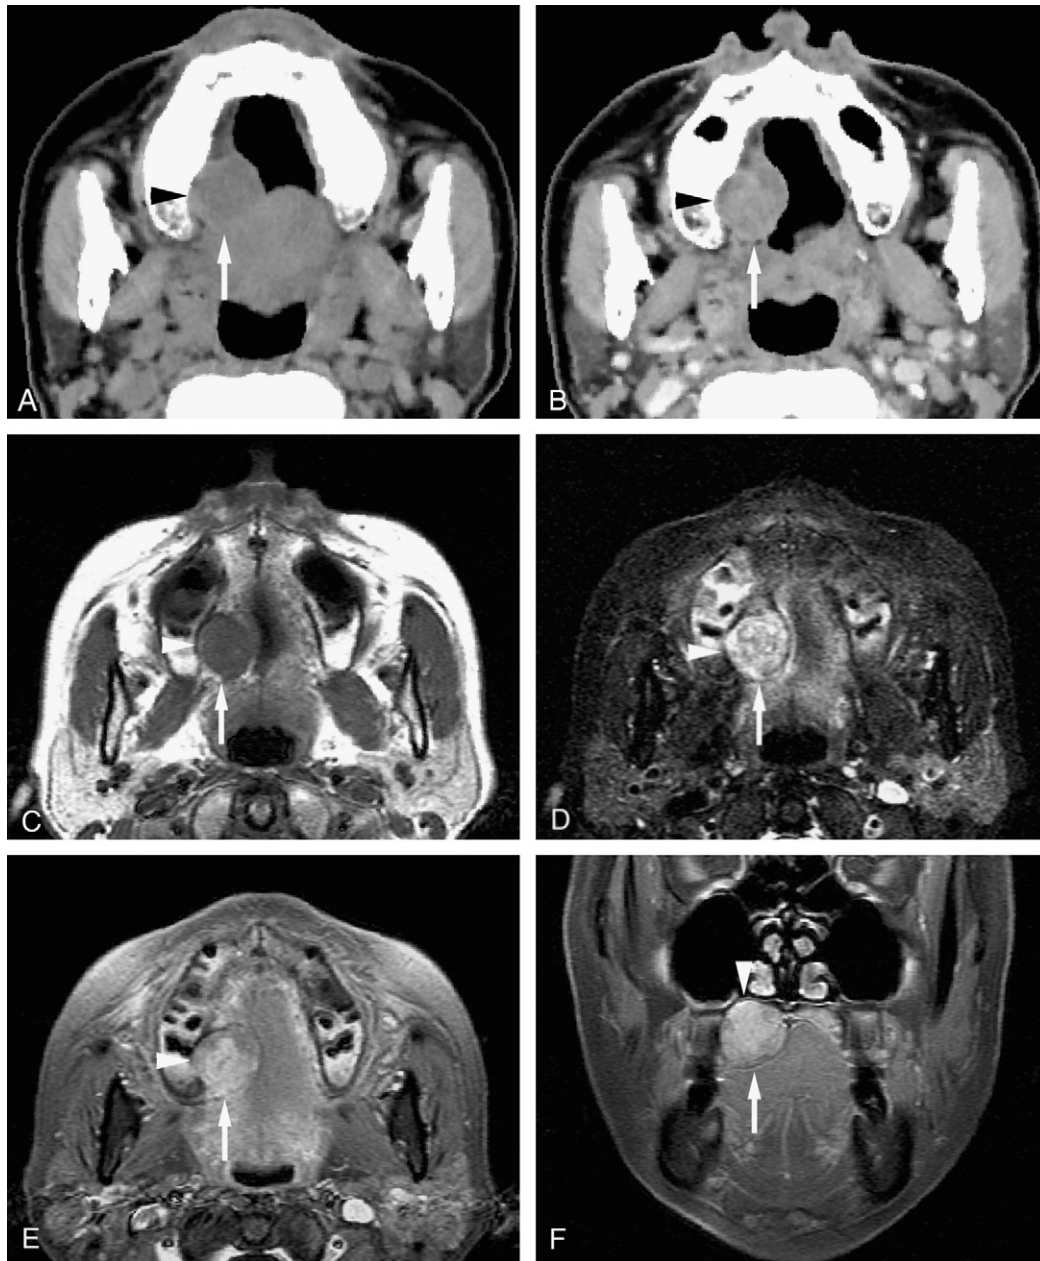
Pleomorphic adenoma of the palate in a 59-year-old male. The well-defined margin and smooth border tumor (arrows) and bone resorption (arrowheads) can be detected on CT and MR images. (A) The tumor shows inhomogeneous intermediate signal intensity on a plain CT image. (B) After contrast medium administration the tumor shows an inhomogeneous enhancement on a CE CT image. (C) The T1-weighted MR image shows an intermediate signal intensity mass. (D) The T2-weighted MR image with FS technique shows inhomogeneous high signal intensity mass. (E) After contrast medium administration the tumor shows an inhomogeneous enhancement on the CE T1-weighted image using the FS technique. (F) Bone resorption of the palatal bone can be detected on a coronal CE T1-weighted MR image using the FS technique.
